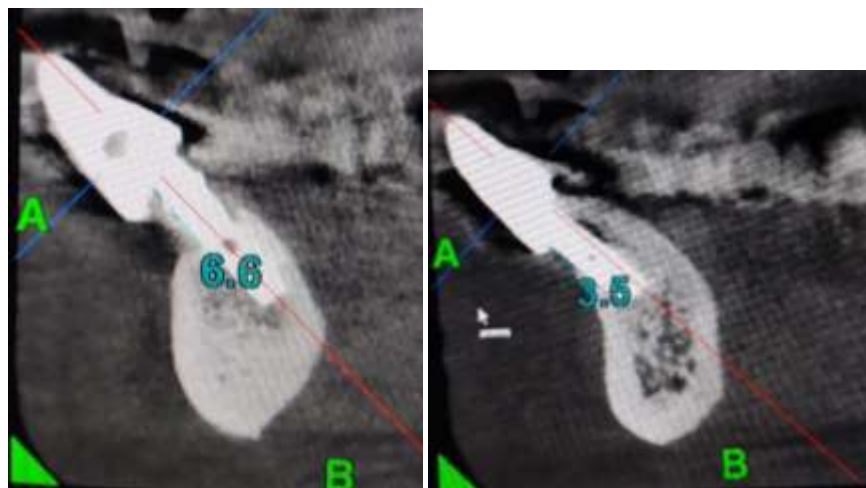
At Baseline Pre Operative CBCT WRT 31 & 41.
